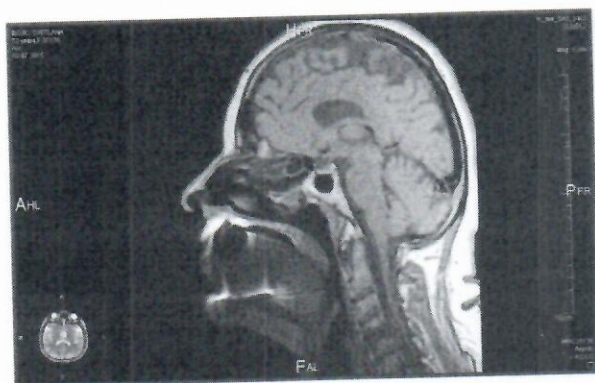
MRI - Volume of the pharynx after therapy.
